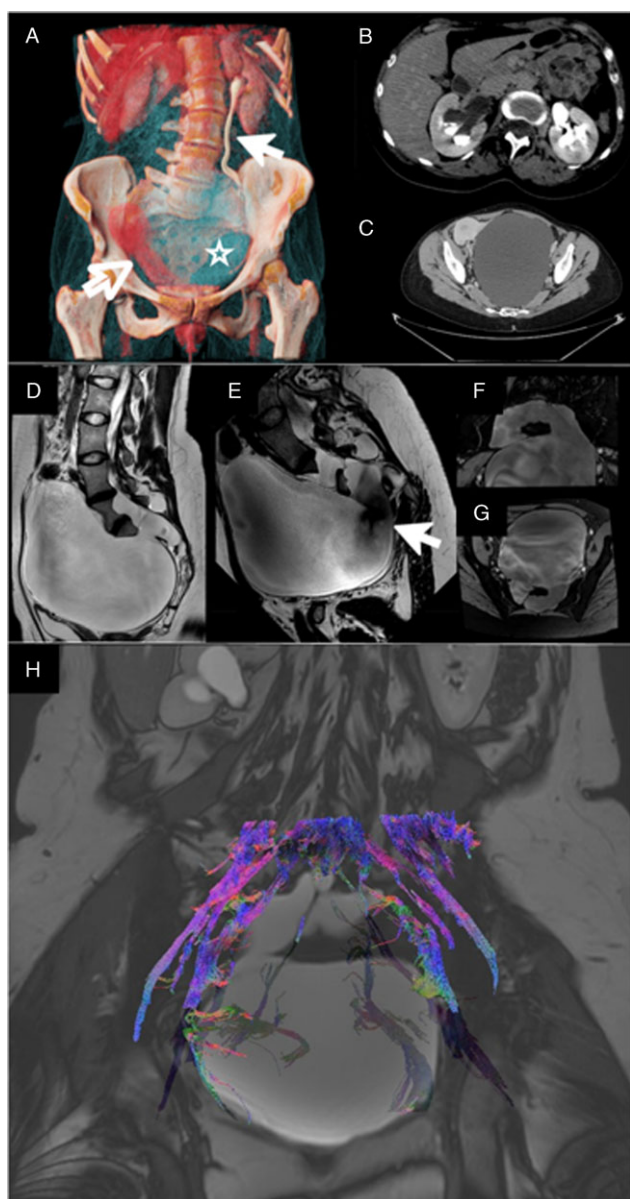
(A) Cinematic rendering of the abdominal CT showing the anterior meningocele (light blue, void star), the displaced uterus (red, void arrow), dilatation of the left ureter (white arrow) and the absence of contrast media elimination from the right kidney. (B) Axial section of the renal pelvis. (C) Axial section of the pelvis. (D) The sagittal T2-weighted sequence shows the extent of the meningocele. (E) Flow-sensitive T2 sequence shows the flow void, highlighting the communication with the spinal canal (void arrow). (F,G) High-resolution steady-state free precession isotropic imaging clearly depicts the anatomy of the communication with the spinal canal, with the possibility to generate multiplanar reconstruction to better plan the surgery. (H) Fiber tracking calculated from diffusion tensor imaging (DTI) superimposed on a low-resolution steady-state sequence. The fibers are color coded for direction: blue for craniocaudal, green for lateral and red for anterior posterior. This image aided the surgeons to avoid nerve roots, especially S2, which was intraoperatively compressed near the foramen.
